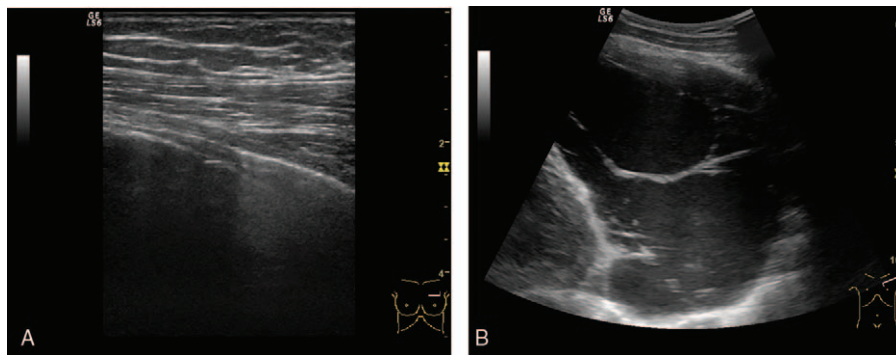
A, Left parasternal echo free lesion with thin wall displacing laterally the ventilated lung—mediastinal cyst. B, Large left parasternal echo free lesion with thin septa and walls—mediastinal cyst.
